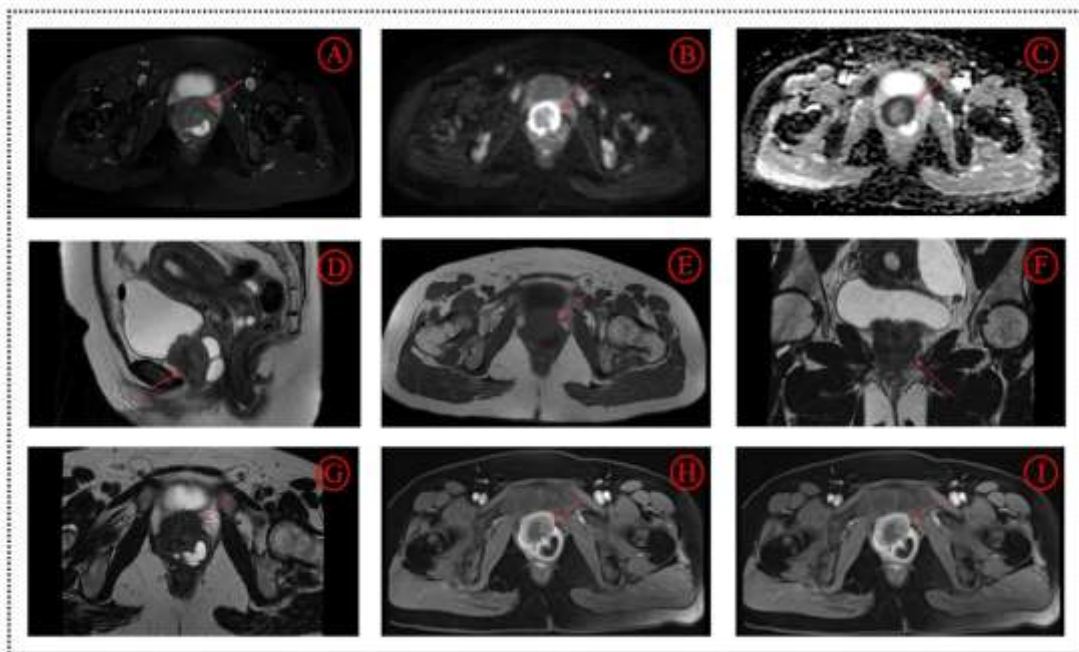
MRI Images of NEC. The lesion exhibits isointensity on T1WI (Image E), isointensity to slightly hyperintensity on T2WI (Images D, F, G), and slightly hyperintensity on T2WI FS (Image A); the periphery of the lesion shows marked hyperintensity on DWI (Image B) with corresponding hypointensity on ADC maps (Image C); and on contrast-enhanced scanning, the lesion presents obvious heterogeneous rim enhancement while the central part of the lesion shows weak enhancement (Images H, I).
